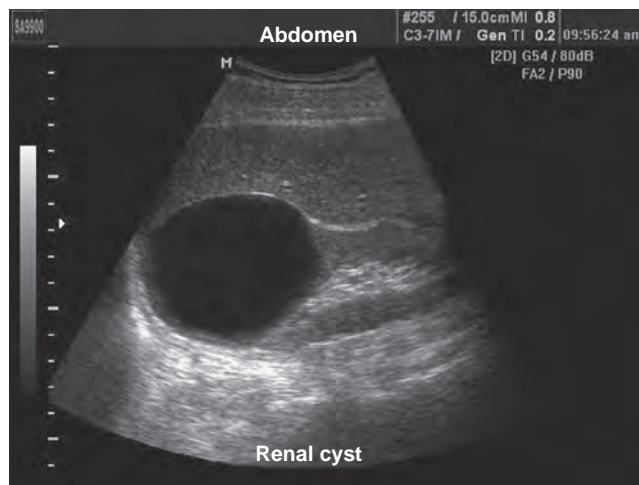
Ultrasonographic appearance of a 4-cm simple renal cyst. This meets the definition of a true simple cyst: (1) absence of internal echoes; (2) sharply defined, thin, distinct wall with a smooth and distinct margin; (3) good transmission of sound waves through the cyst with consequent acoustic enhancement behind the cyst; and (4) spheric or slightly ovoid shape.
